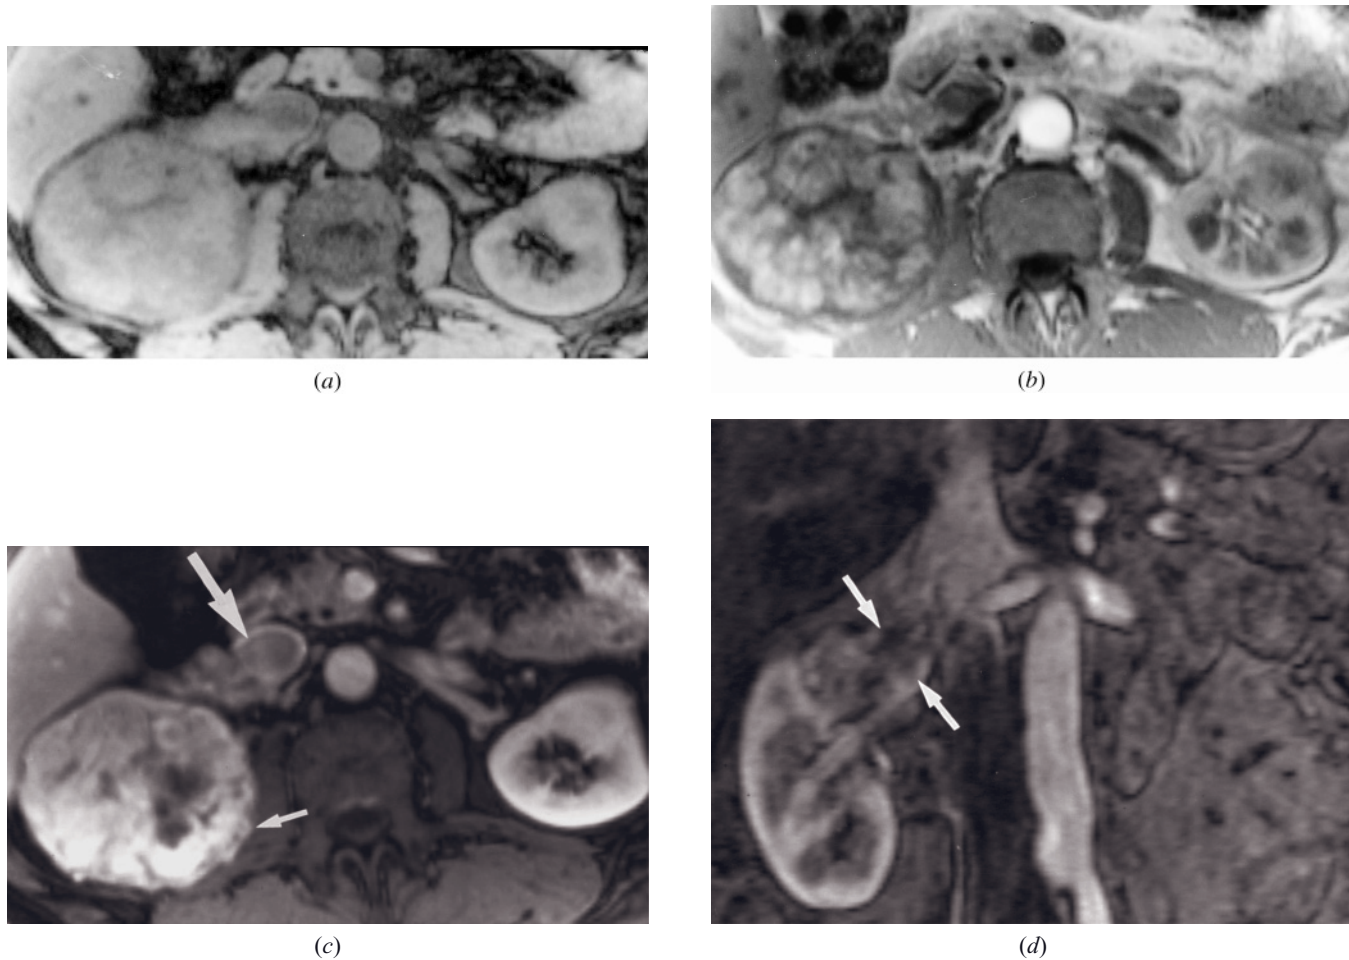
Renal cell cancer—Stage 4a. T1-weighted precontrast fat-suppressed (*a*) and immediate (*b*) and 2-min fat-suppressed (*c*) postgadolinium SGE images and coronal source image for an MRA (*d*). A large cancer arising from the right kidney is present that shows intense heterogeneous enhancement on immediate postgadolinium images (*b*), foci of central necrosis (*c*), tumor thrombus (long arrow, *c*; arrows, *d*), and invasion of the right psoas muscle (short arrow, *c*).
